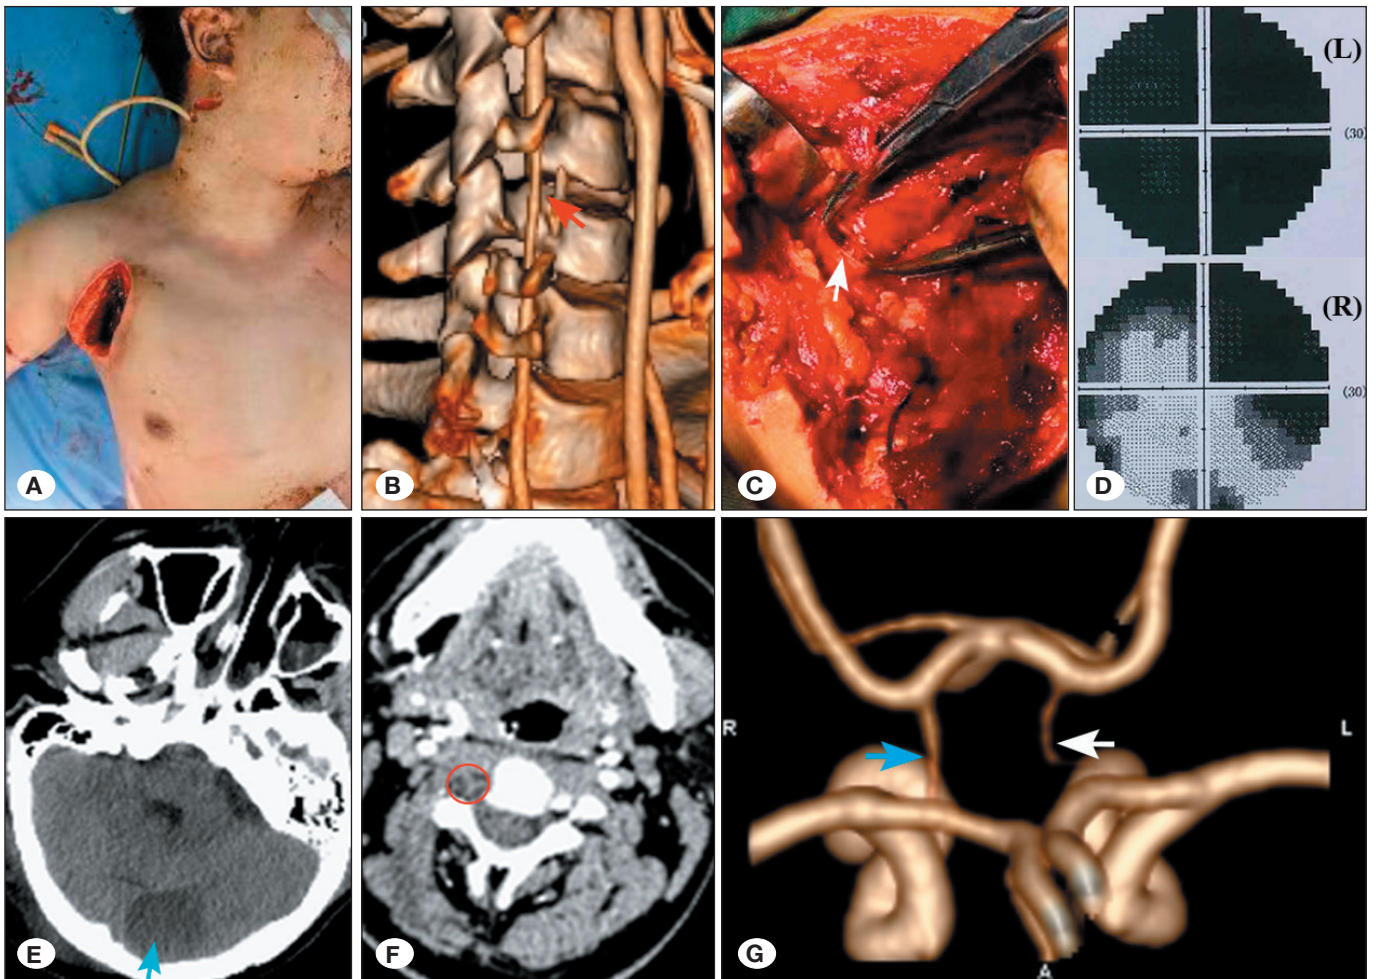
Pre-, intra-, and postoperative images of case 2. A) Foley catheter with a balloon tamponade was used to control the hemorrhage. B) Preoperative CTA showing injured segments of the right VA (red arrow). C) Laceration of proximal esophagus (white arrow). D) Grayscale visual field analysis showing complete left eye blindness and right homonymous hemianopsia (upper panel: left eye; lower panel: right eye). E) Postoperative non-contrast cranial CT imaging showing an ischemic infarction in the left occipital lobe (blue arrow). F) Postoperative occlusion of the injured VA segment (red circles). G) CTA showing occlusion of the left PComA (white arrow) and hypoplasia of the right PComA (blue arrow). CT: Computed tomography; CTA: Computed tomography angiography, VA: Vertebral artery; PComA: Posterior communicating artery.
